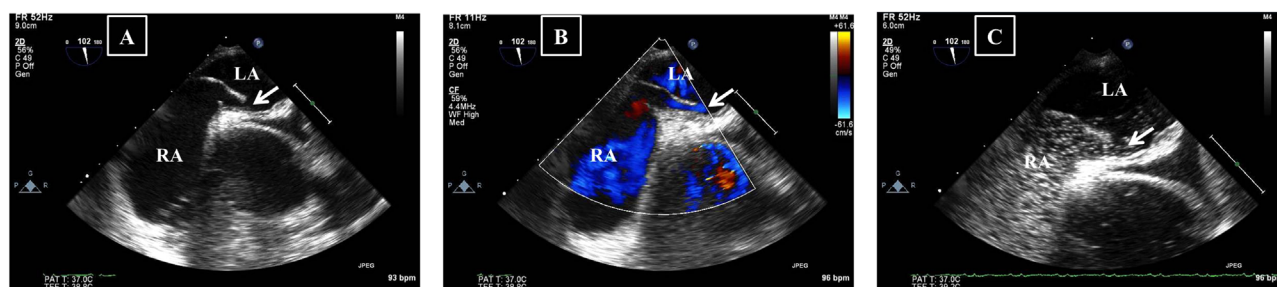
Diagnosis of a PFO by TEE. (A) Direct visualization of PFO by TEE. The septal separation is visible (arrow). (B) TEE visualization of shunt through the PFO (arrow) by color Doppler. (C) Agitated saline contrast study of TEE. Microbubbles are seen entering the LA through the PFO (arrow). LA, left atrium; PFO, patent foramen ovale; RA, right atrium; TEE, transesophageal echocardiography.
